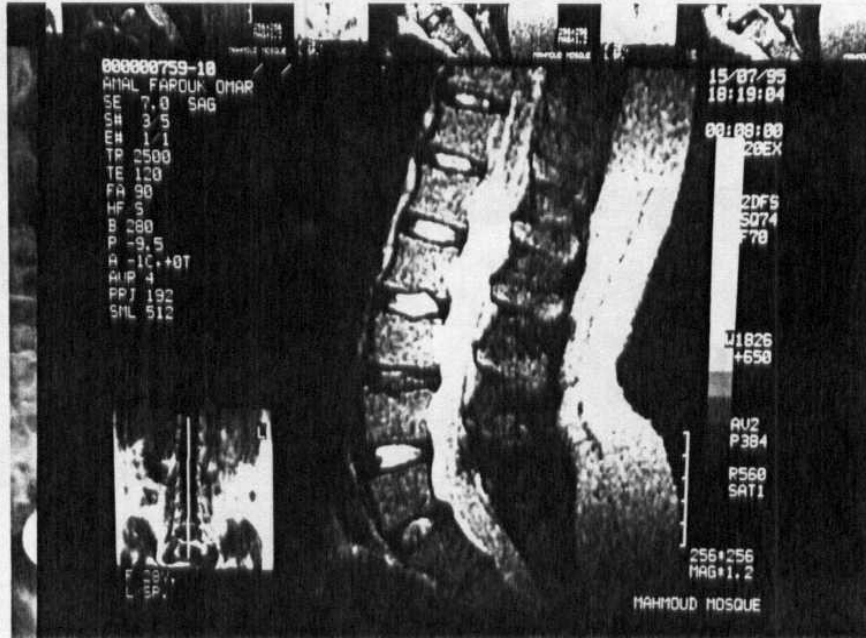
MRI showing multiple disc affection. Which disc was causing the symptoms??. The Myelography showed that two roots on one side were affected (L45 and L5S1).
